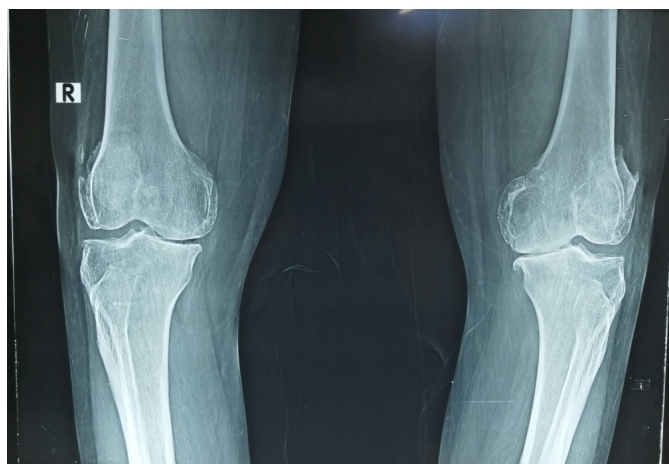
X-ray Knees (AP view)
